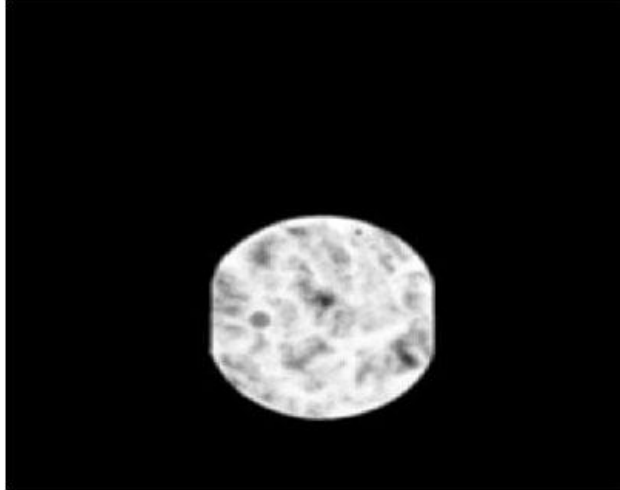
CT image low-passed filtered with a $5 \times 5 \times 3$ kernel.
